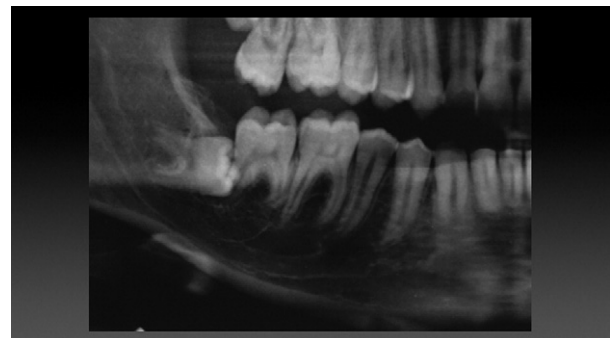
Partial panorex radiograph of a 19-year-old male patient at the initial consultation. The right mandibular third molar is horizontally impacted, and the patient complained with pain and discomfort at the area. The apex of the mesial root is in the proximity of the alveolar canal.
